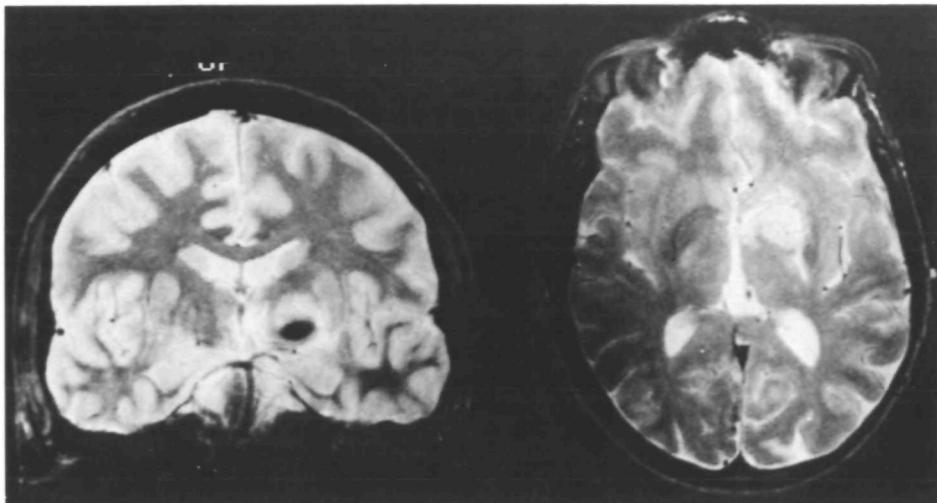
Magnetic resonance images, coronal and transverse sections showing low T1 signal in left globus pallidus. Left side of body appears on right side of figure.
